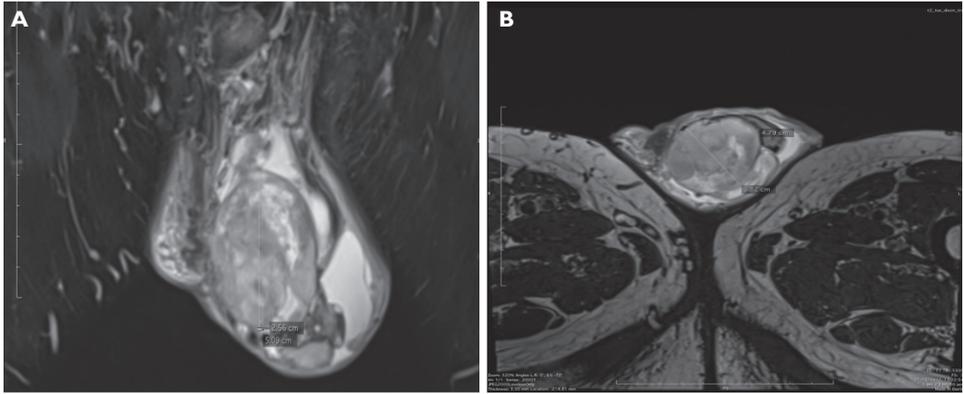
Sagittal and transverse magnetic resonance images.
